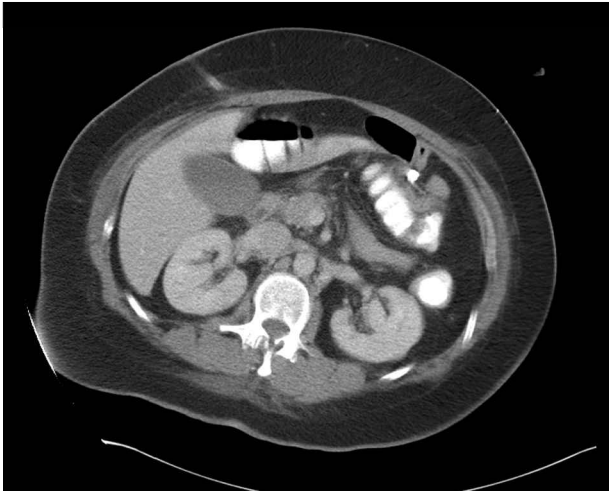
Free air pocket shown by white arrow on CT scan.
